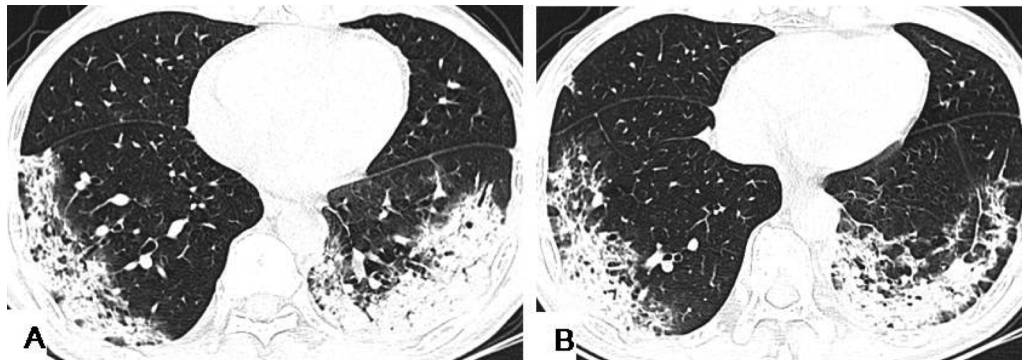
A 63-year-old female presented with an 8-day history of fever with occasional cough. HRCT showed large consolidating shadows in the lower lobes of both lungs with interlobular septa thickening, and the lower lobe lesions involved the central zone.
